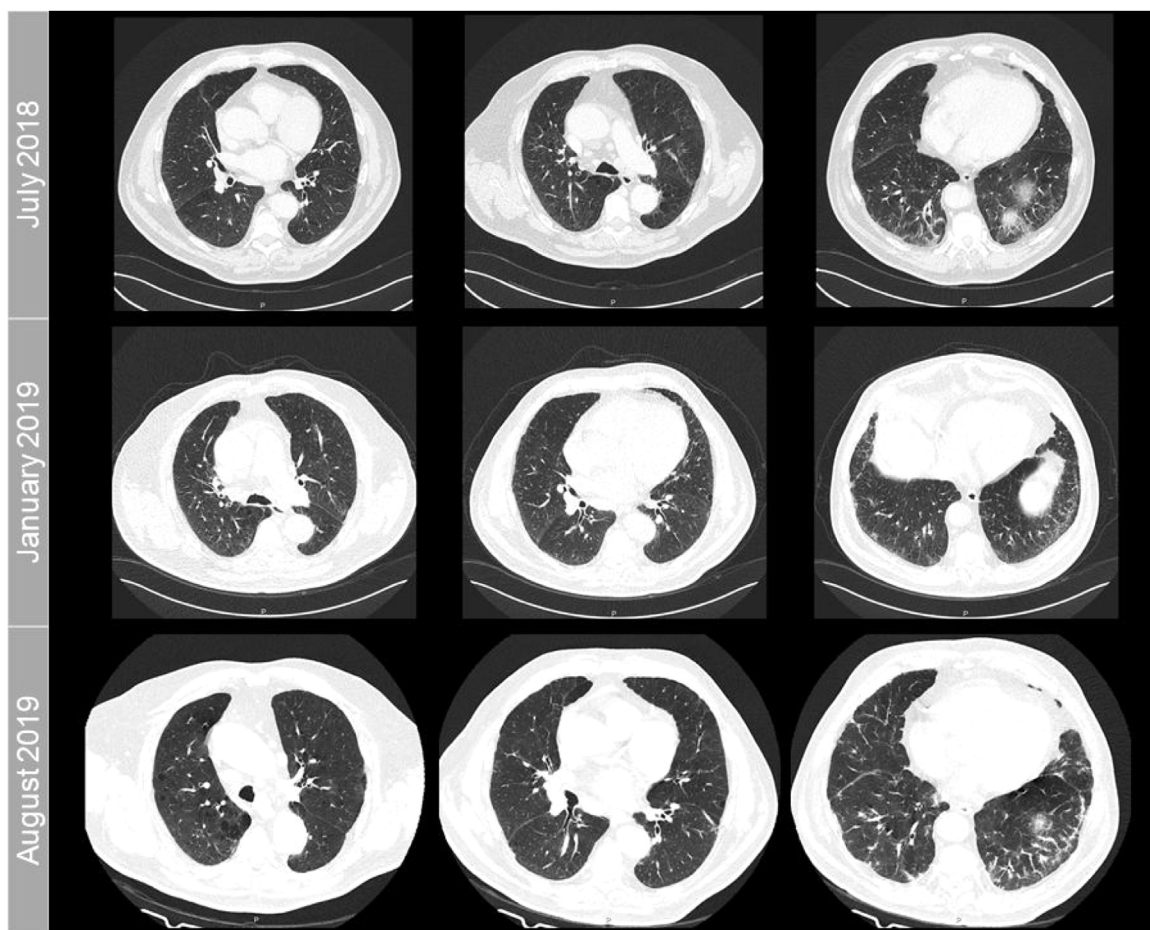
Follow-up chest CT scan axial images showing progressive, unspecific peripheral intralobular reticulation in the lower lung lobes. The time when the scans were performed is indicated on the left of each row of images. For comparative purposes, the images in each column correspond to identical axial planes.
